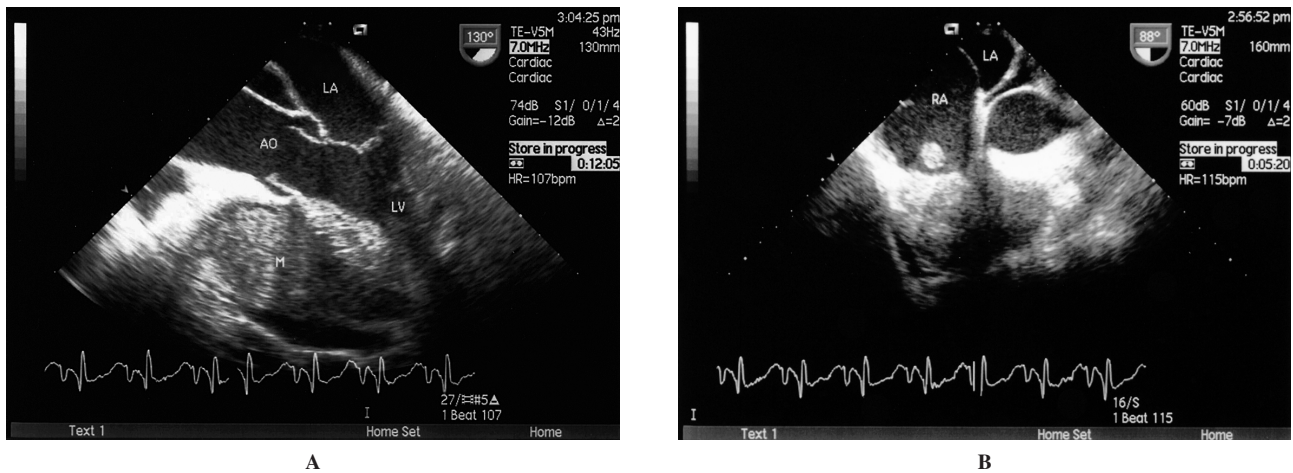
Transesophageal imaging of right ventricular invasion by the tumoral mass (M) (A) and protrusion of the mass into the right atrium (RA) (B). AO = aorta; LA = left atrium; LV = left ventricle.
